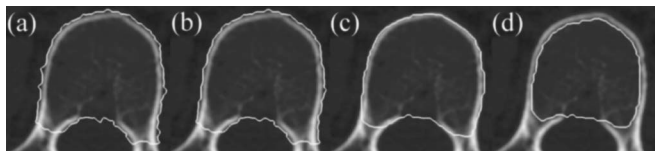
Segmentation algorithm stages. 2D axial slices of computed tomography scans are depicted with a contour representing the current stage of segmentation: (a) initial demons segmentation of the exterior surface of the vertebral body, (b) the initial segmentation of the exterior surface of the vertebral body after refinement by level set, (c) the result of contracting the surface within the cortical shell by level set, and (d) the segmentation of the trabecular centrum after final processing with the level set filter.
